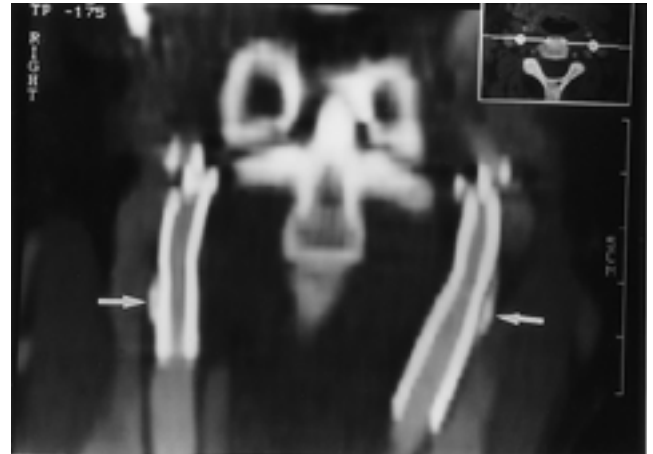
51-year-woman underwent bilateral carotid stents(right: 8 × 20mm, left: 8 × 30mm) placement. Calcified atheromas(arrows) between stent and arterial wall are well defined in MPR image of CT angiography.
